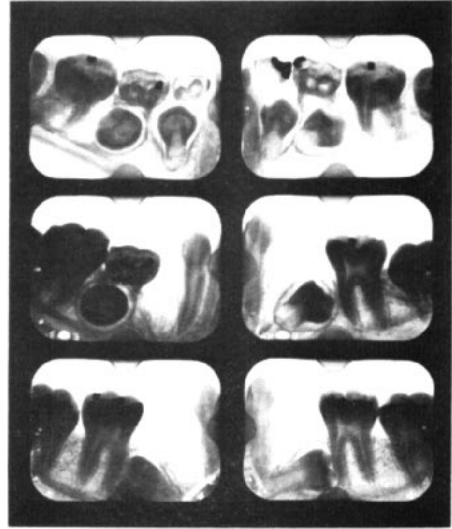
Horizontal impactions possibly resulting from early serial extraction. Right and left lower posterior apical x-rays. Top, age 10:9, Middle, 11:9, Bottom, age 14:4.
